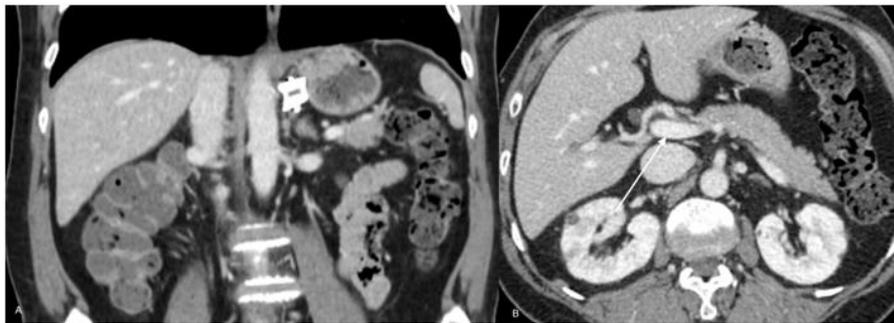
(A) CT scan performed 1 month after the procedure confirming shunt exclusion with correct vascular plug placement. (B) Portal vein with regular diameter is shown upon restoration of blood flow.
